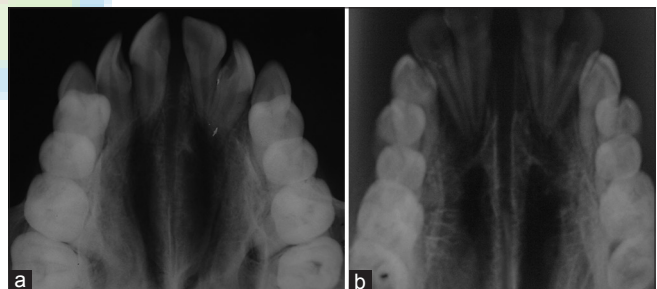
Posttreatment occlusal radiograph of (a) fan-type rapid maxillary expansion (b) Hyrax
